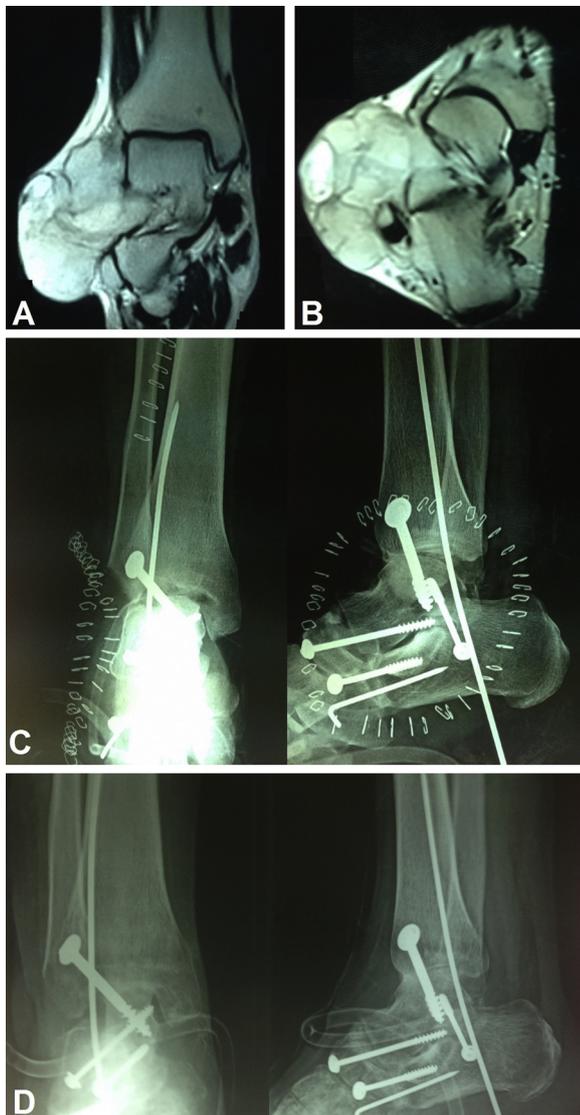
A case of male patient 25 years old with synovial sarcoma of the hindfoot and ankle. MRI showing the mass is lying on the calcaneus and talus with extension into the subtalar joint; A) coronal view, B) axial view. Resection included the outer part of talus, calcaneus and distal fibula. C) Immediate postoperative X-rays showing pan-talar fusion by screws and K-wires. D) Four months postoperative X-rays showing ankle and subtalar fusion with no recurrence (N.B. the tube is the suction tube of the wound vacuum system).
